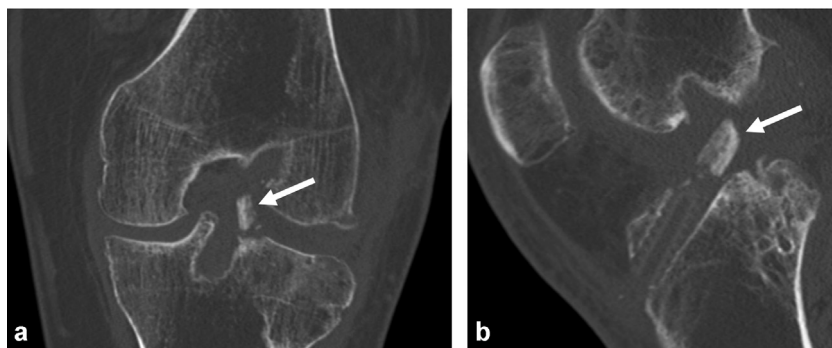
Intra-articular migration of tibial bone graft (arrows) right after a BTB reconstruction. Coronal (a) and sagittal (b) CT images.
